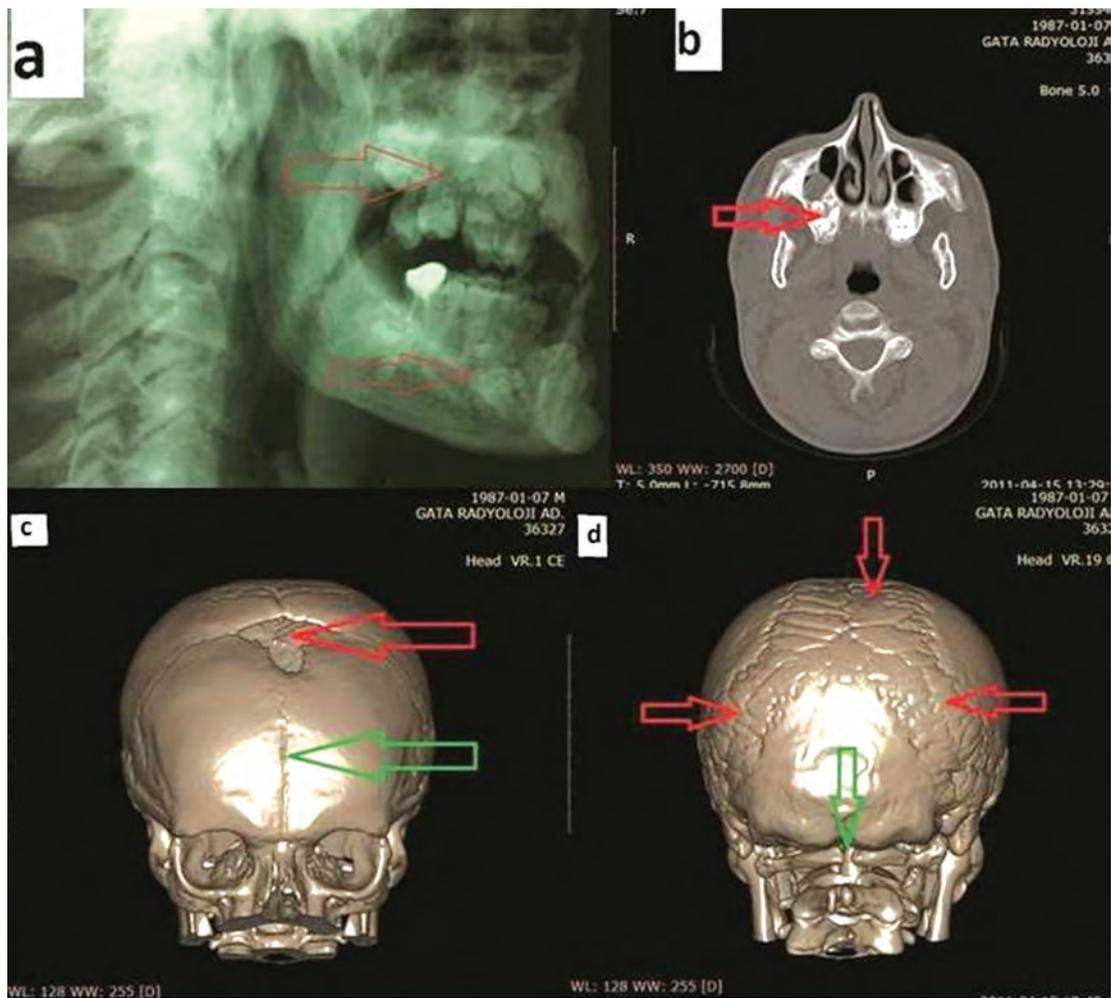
Plain radiographic demonstration of delayed permanent teeth in both jaws (a), and CT scan showing unerupted permanent teeth in the maxilla (b). CT scan showing the delayed closure of the frontal fontanel (red arrow) and frontal groove, resulting from incomplete ossification of metopic suture (green arrow) (c). CT Scan showing the broad sagittal and lambdoid sutures and wormian bones close to lambdoid sutures (red arrows), and open posterior arcus of the axis because of delayed ossification (green arrow) (d).
